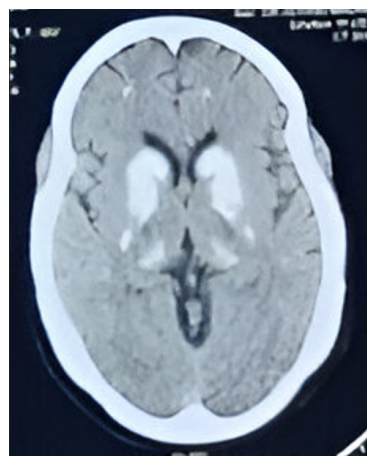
depicts bilateral diffuse hyperdense basal ganglia calcification in non-contrast computed tomography (NCCT) brain of a 50 years old female patient with multisystemic involvement and neuropsychiatric manifestations
